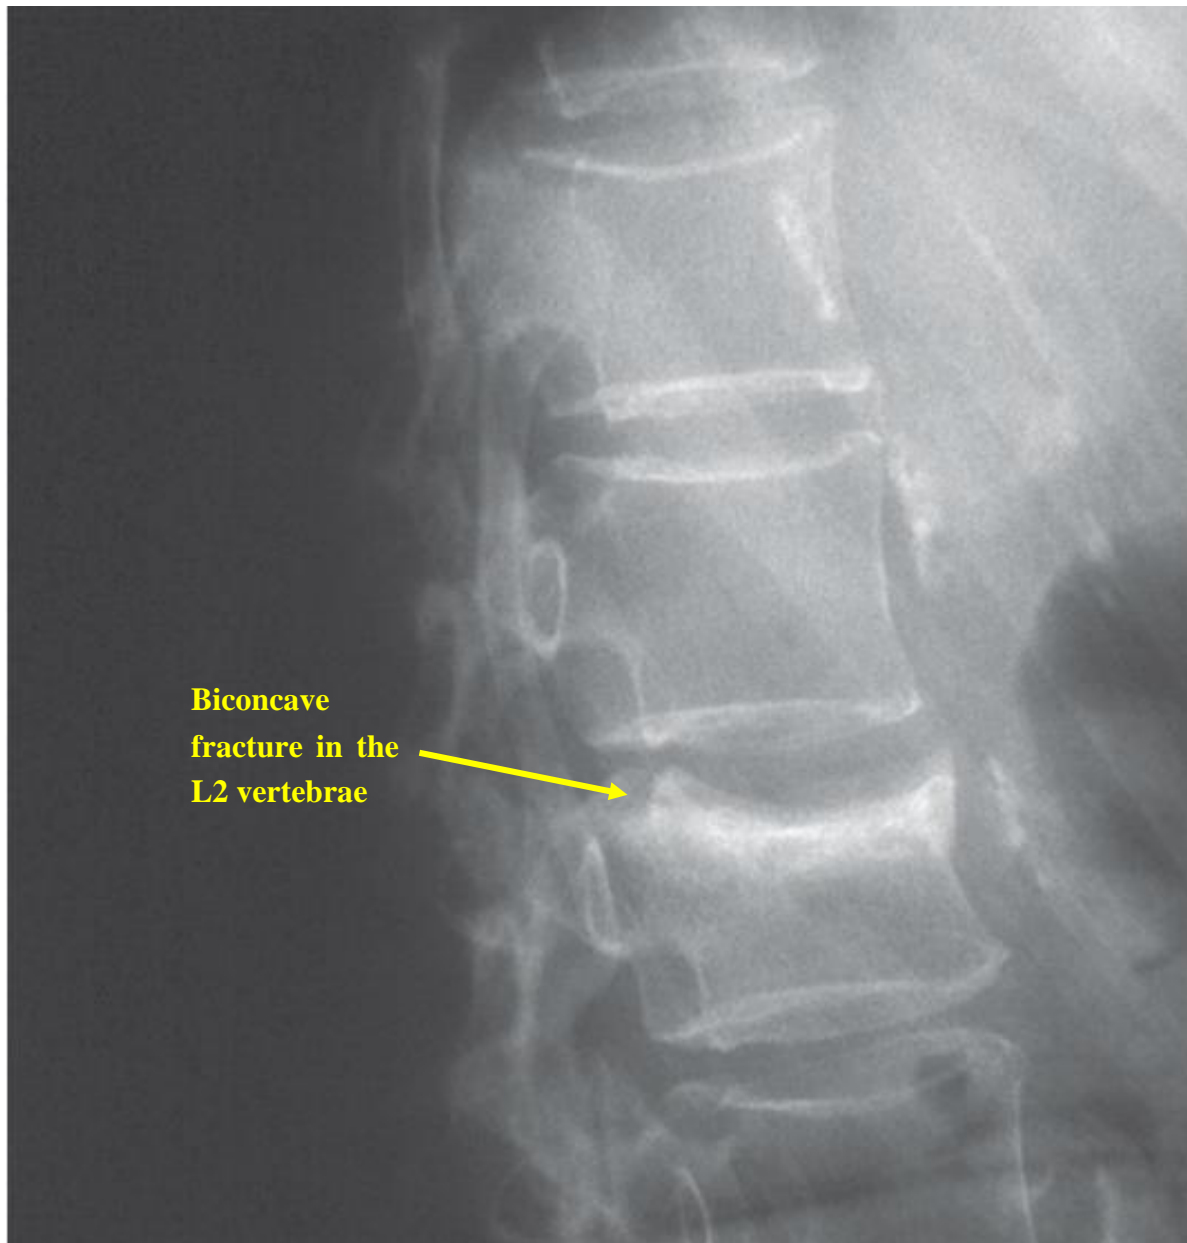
Lateral radiograph of the spine and a biconcave fracture in the L2 vertebrae. Source: Ensrud KE, Schousboe JT (2011) Vertebral Fractures. *New England Journal of Medicine* 364:1634-1642.
